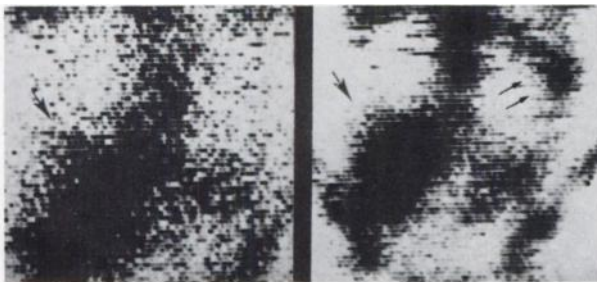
Early (6-hr, left) and delayed (48-hr, right) anterior ^{67}Ga scintigraphs demonstrating large right psoas abscess. Note residual bowel activity in delayed study despite administration of laxatives on 2 successive days (double arrows).
